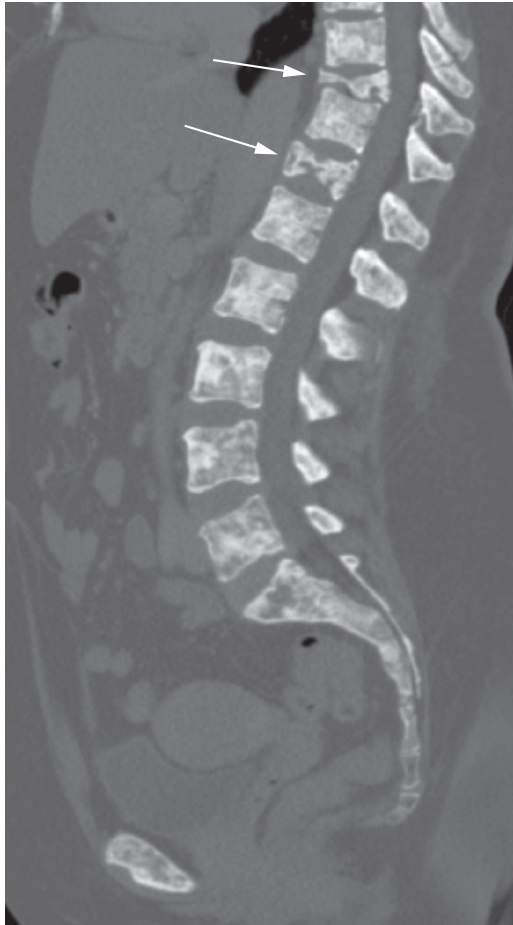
Metastases. CT sagittal reconstruction in a patient with carcinoma of the breast showing multiple mixed, but mainly sclerotic, metastases in the thoracic and lumbar spine. There are pathological wedge fractures in two of the lower thoracic vertebrae (arrows).
